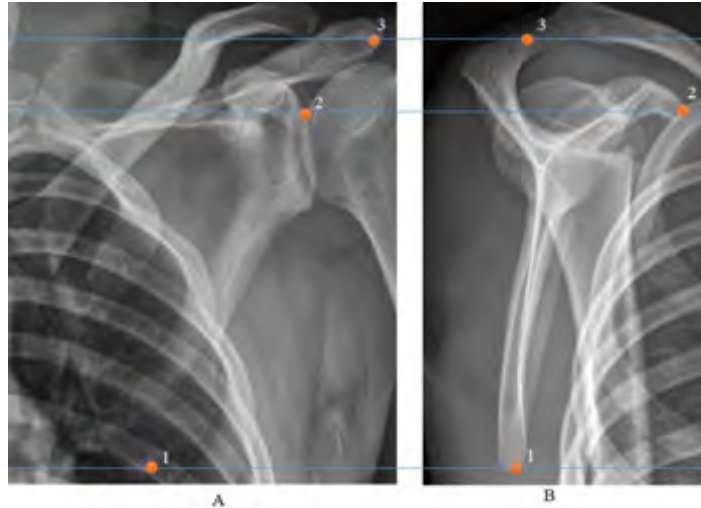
Selected reproducible landmarks of the scapula. (A) AP and (B) Oblique lateral shoulder radiography. (1) Inferior angle, (2) Coracoid process and (3) Acromion.
